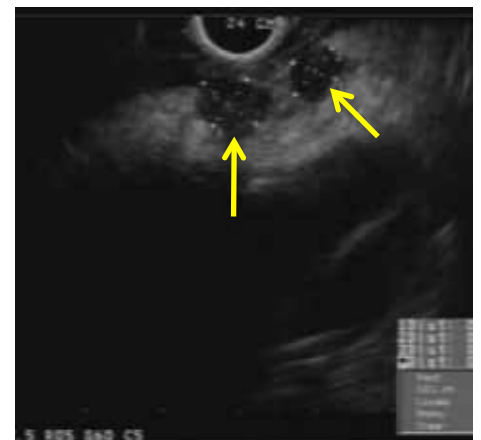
Endoscopic ultrasound showing malignant-appearing lymph nodes in the right upper paratracheal area.
